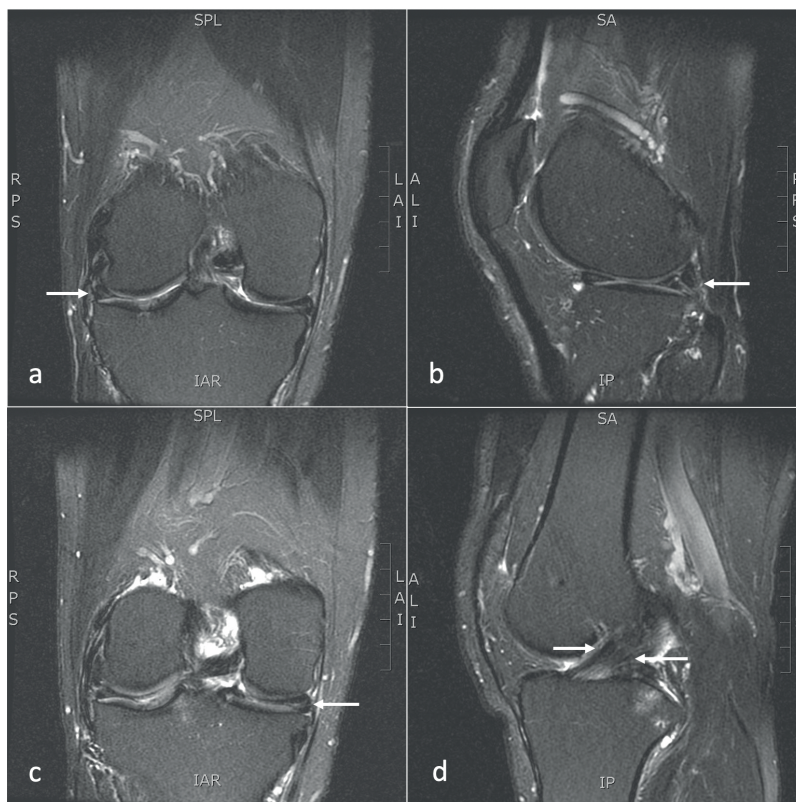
(a) Sagittal and (b) coronal T2-weighted magnetic resonance imaging (MRI). Arrows indicate longitudinal horizontal oblique tear of the lateral meniscus (linear white signal within black meniscus). (c) Coronal T2-weighted MRI. Arrows indicate horizontal longitudinal medial meniscal tear with similar white signal intensity. (d) Sagittal T2-weighted MRI. Arrows indicate thickened anterior cruciate ligament (ACL) compatible with chronic low-grade injury/sprain
